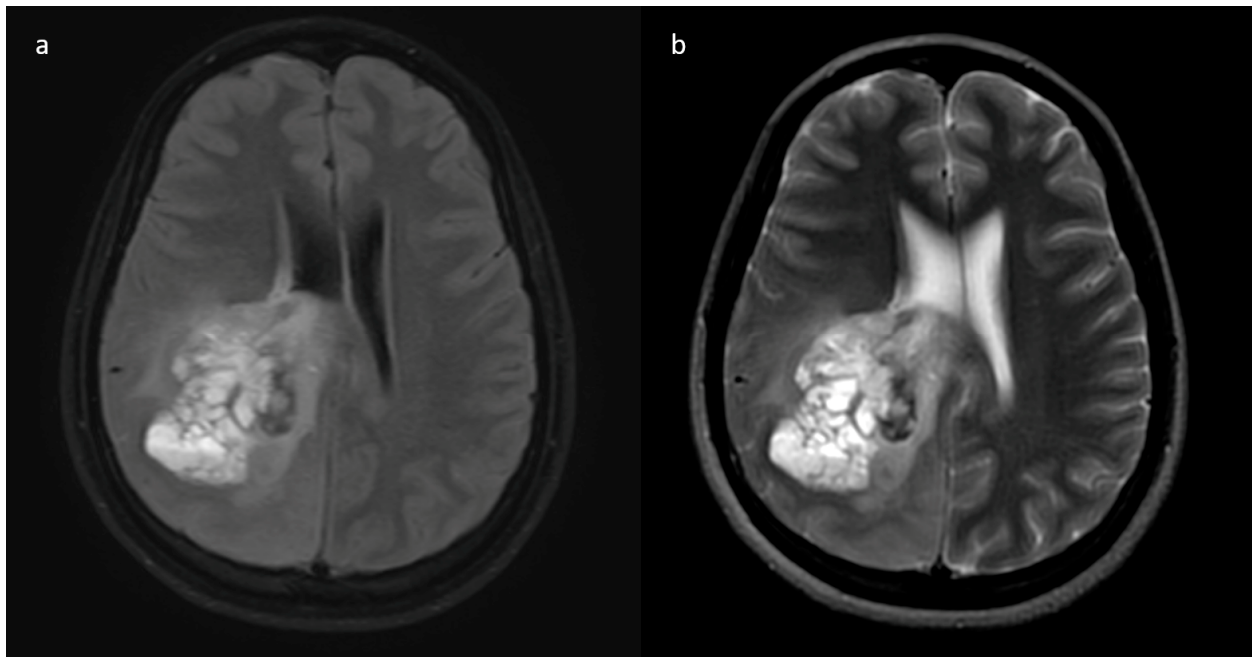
(a,b) Axial T2w and FLAIR images reveal intratumoral cysts with fluid-fluid levels within these cysts, suggestive of a hemorrhage.
